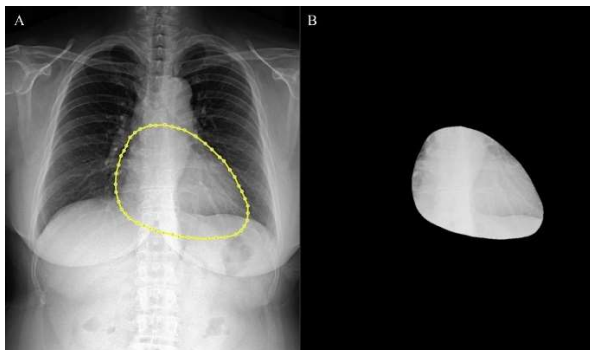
Example of region of interest on posteroanterior chest X-ray radiographs (CXR). (A) is an example of cardiac annotation by the expert. (B) is a cardiac segmented image.
